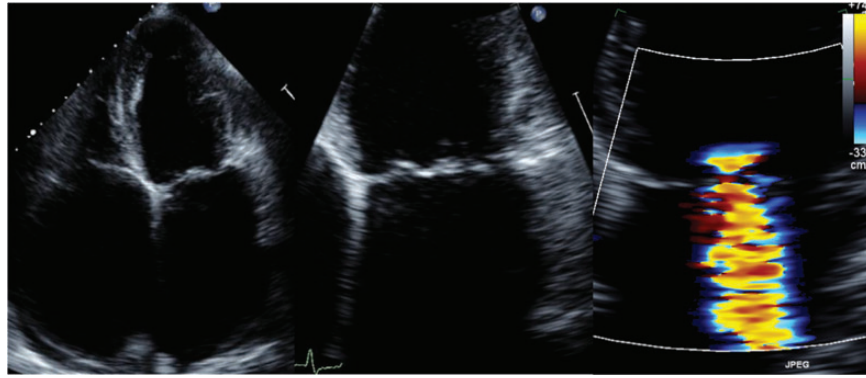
Left pane depicts a 2D transthoracic image of a patient with atrial MR. Both atria are significantly dilated, but the LV dimensions are normal. In the zoomed image (centre), note how the mitral leaflets sit almost level with the annular plane: there is no tenting or prolapse. The image on the right shows the associated regurgitation.
